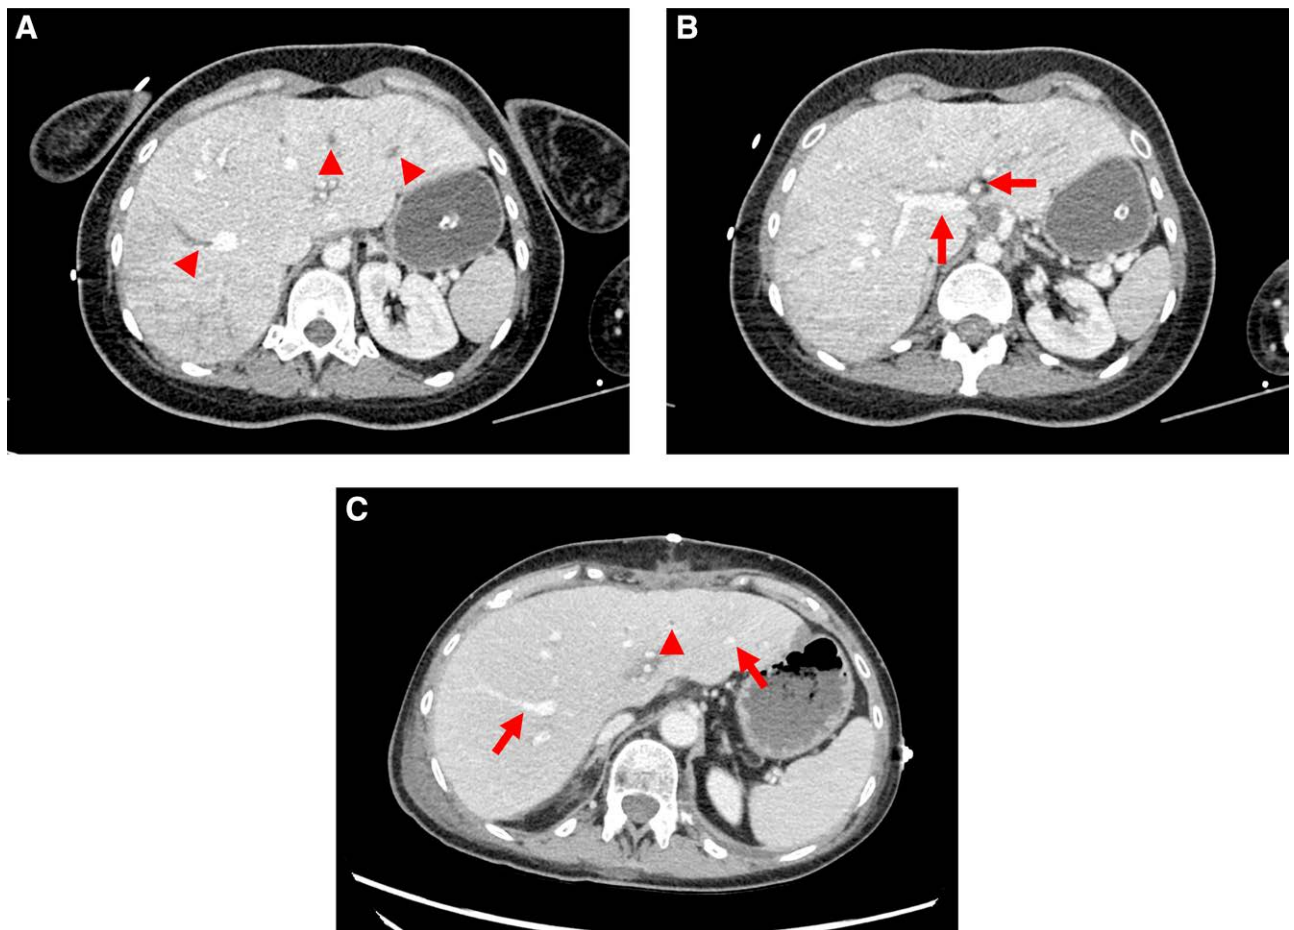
Donor and Recipient computed tomography. (A, B) Preoperative donor computed tomography showing thrombosis of peripheral tributaries of the right, middle, and left hepatic veins (arrowheads) and patent portal vein and hepatic artery (arrows). (C) Postoperative recipient computed tomography highlighting resolution of peripheral thrombosis in right and left hepatic vein tributaries (arrows), with persistence of a thrombus in a scissural branch of the middle hepatic vein (arrowhead).
